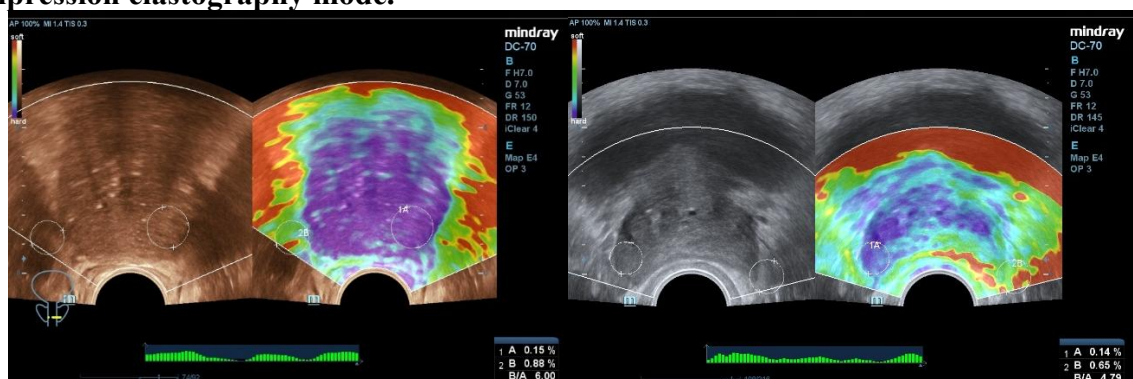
Prostate cancer (PCa). Transrectal ultrasound (TRUS) in the compression elastography mode.
